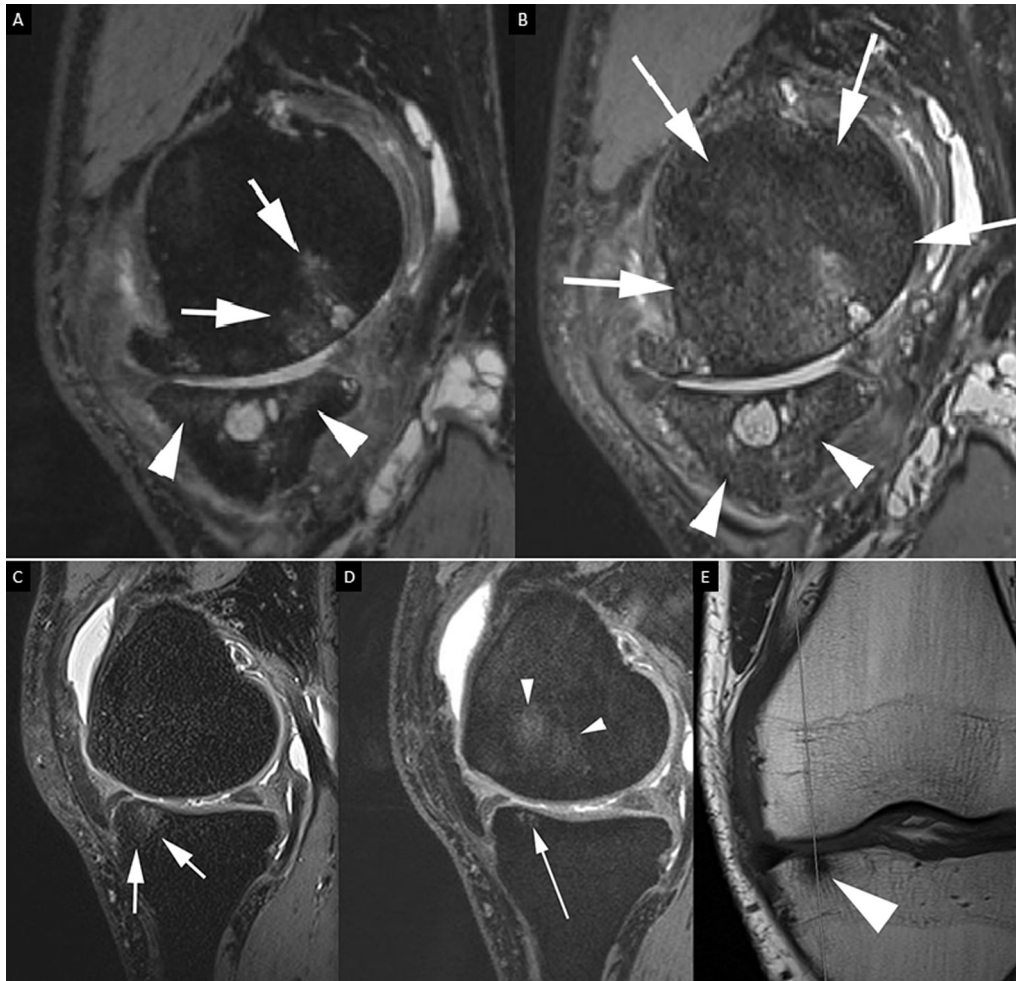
Direct comparison between different sequences used in the current study. (A) Sagittal DESS image shows cystic portion of femoral and tibial bone marrow lesions (BML) and some ill-defined parts of BML in both, femur (arrows) and tibia (arrowheads). (B) Sagittal SPACE, a 3D T2-weighted FSE fat suppressed fast spin echo sequence, superiorly depicts ill-defined BMLs that are visualized in much larger fashion in femur (arrows) and tibia (arrowheads) compared to DESS. (C) Sagittal SPACE image in another patient shows a BML in the anterior medial tibia (arrows). No bone marrow changes are seen in the femur. (D) Corresponding sagittal DESS shows tibial BML to a much smaller extent compared to SPACE (long arrow). High intensity signal changes in the medial femur represent artifacts as a result of popliteal vessel pulsation and must not be mistaken as bone marrow lesions (small arrowheads). (E) Corresponding coronal T1 weighted image shows tibial BML as a circumscribed hypointensity (large arrowhead). No signal alterations are seen in the femur confirming that signal changes seen in D represent an artifact.
